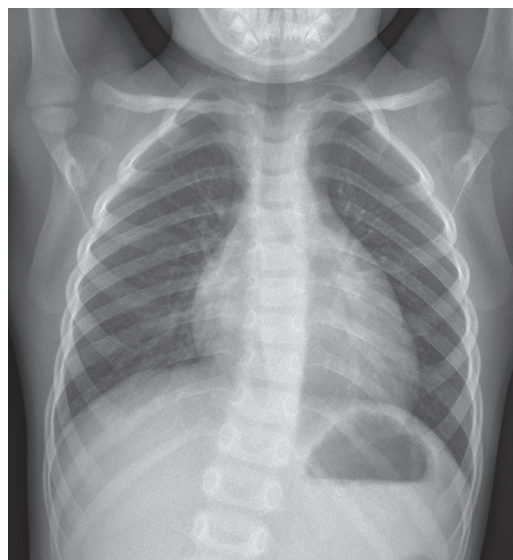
Chest X-ray taken at the time of treatment termination. Normal picture of the lungs
